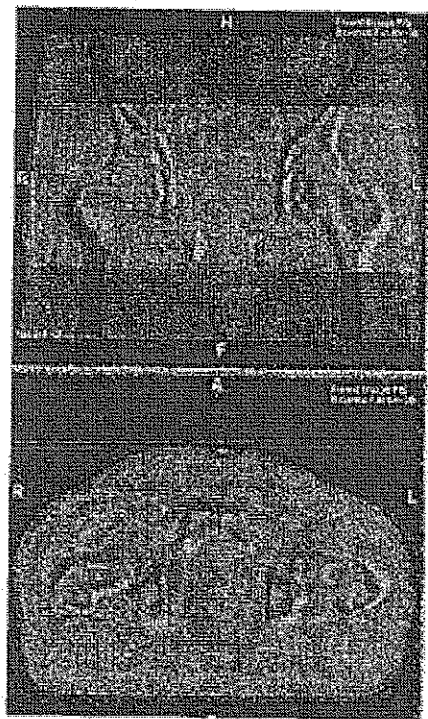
(a) Fusion of MRI and CT data sets, fused images in the top windows and MRI images below. (b) A split screen showing fusion between CT and MRI data sets in quadrants. (Continued)
